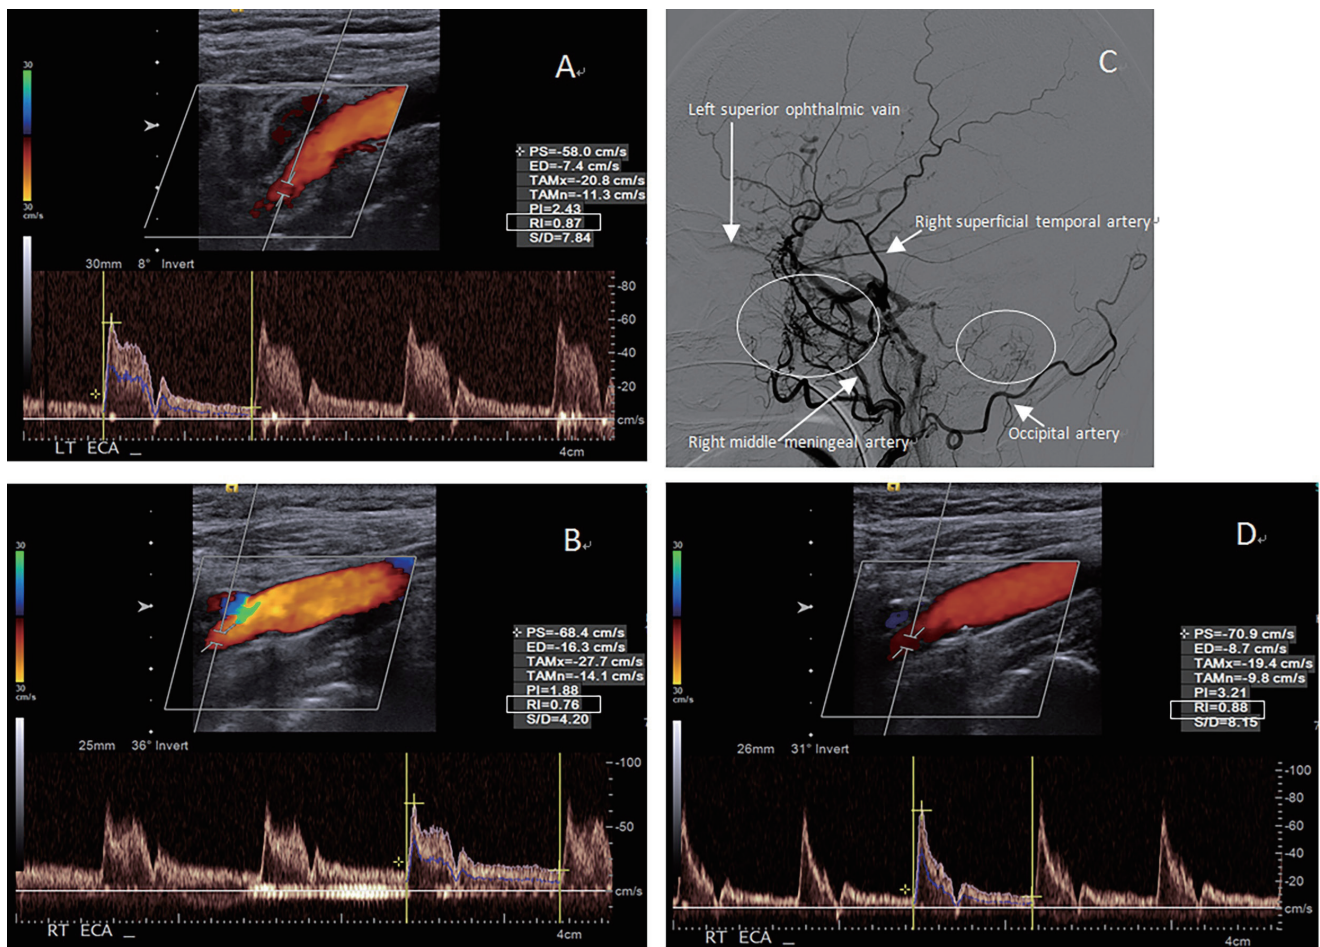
(A,B) Carotid doppler ultrasound revealed high but asymmetric resistance flow in the bilateral ECA (Resistance index [RI] of the right ECA, 0.76; RI of the left ECA 0.87). (C) Diagnostic cerebral angiography demonstrated the main fistulae (the big circle) arising from the right middle meningeal artery, with drainage into the left superior ophthalmic vein, right cerebral vein, and the right cerebellar vein (the small circle); compatible with the obvious alternation resistance flow of the right ECA before and after embolization. (D) RI in the right ECA significantly increased after embolization (before vs. after embolization: RI, 0.76 vs. 0.88).
